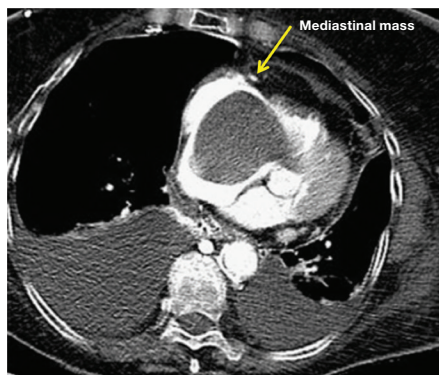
Computed tomography (CT) of chest showing a multilobulated hypoenhancing mass in the anterior mediastinum measuring 6.5 x 5.3 x 3.8 cm. This mass was inseparable from the anterior wall of the superior vena cava.
